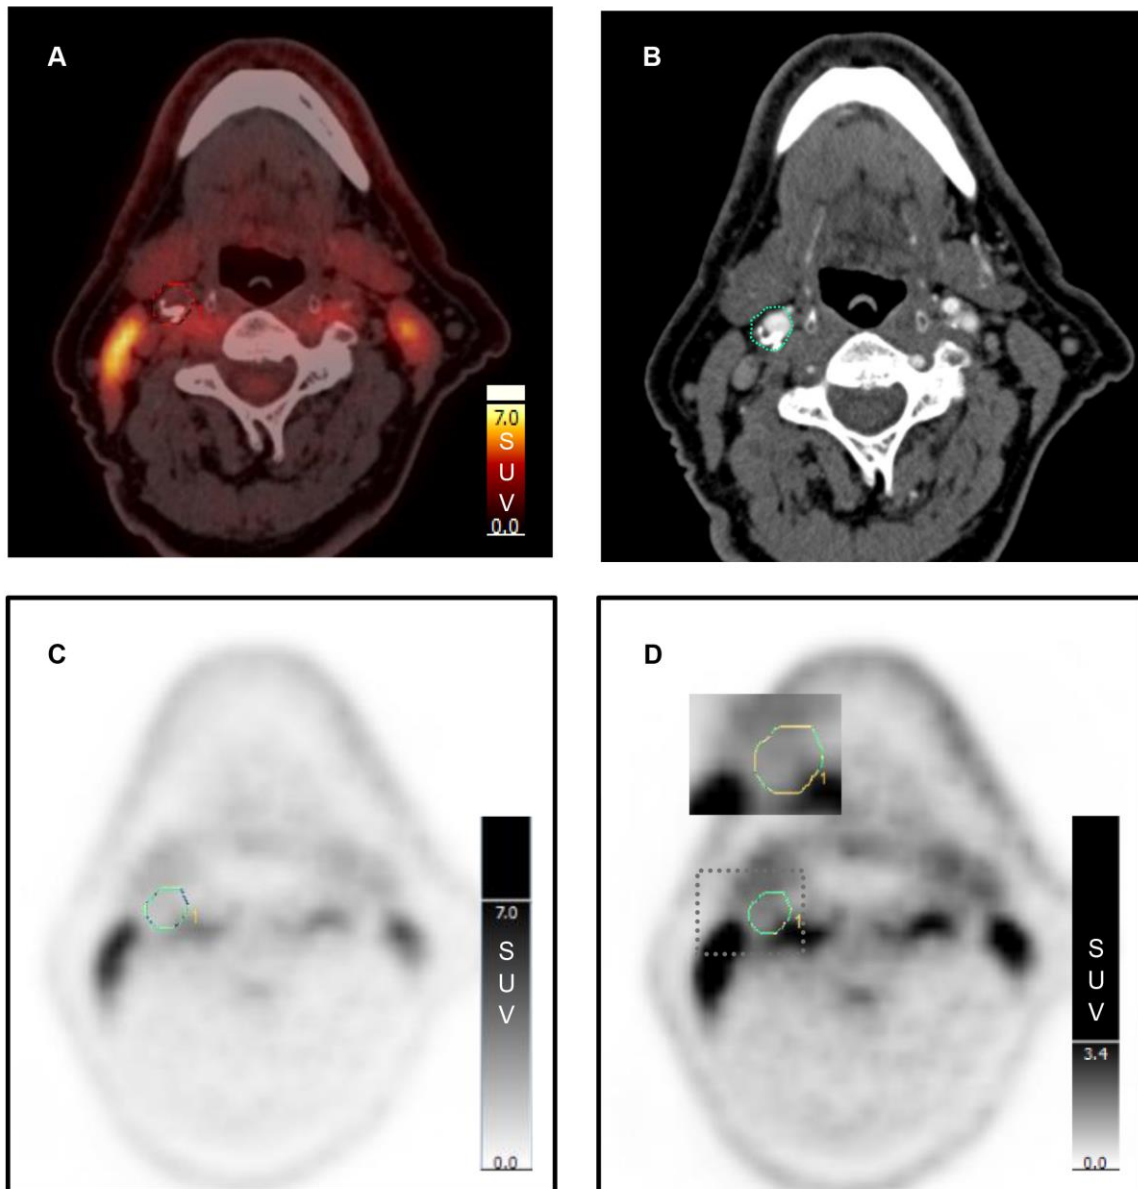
Spill-in activity. Fused image of non-contrast CT and PET (A) and contrast enhanced CT (B) show a plaque in the level of the right carotid bifurcation with low uptake but with high uptake in nearby muscles. PET with normal intensity on the SUV scale (C) and PET with high intensity on the SUV scale (D) show that ^{18}F -FDG uptake from nearby muscle activity influences the ROI around the plaque (inserted picture at 4 to 5 o'clock position).
